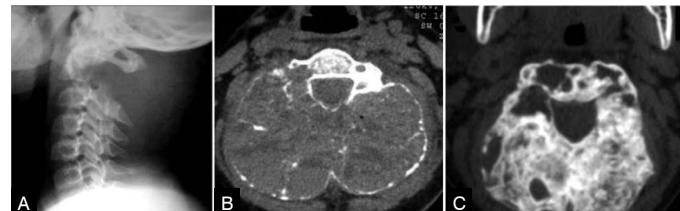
(Case 2) Plain film (A) of the cervical spine shows a soft-tissue mass at the topography of the C2 posterior arch, which is not seen. The CT scan (B) shows the egg-shell-thin cortex and the fluid-fluid levels. Notice the sparing of the cervical canal. The CT scan during the one year long follow-up (C) shows the progressive thickening of the outer cortex and concentric occupation of the cavities with bone until almost complete ossification of the lesion.
